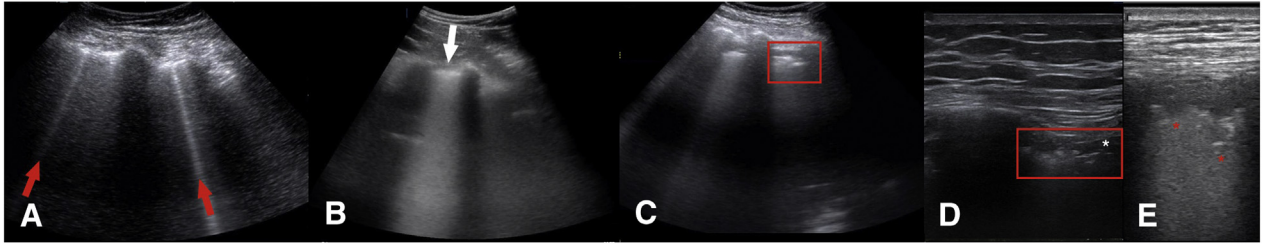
Lung point-of-care ultrasound findings associated with coronavirus disease (COVID)-19 infections. Hyperechoic artifacts originating from the pleural, known as B-lines, are seen ranging from (A, red arrows) isolated to (B, white arrow) confluent. (C) Pleural lines are often irregular (red box), and can be observed alongside (D, white asterisk) peri-pleural edema. (E) Subpleural consolidations (red asterisks) are a hallmark of COVID-19 pneumonia and are often seen in the posterior, lateral, and inferior lung zones.
